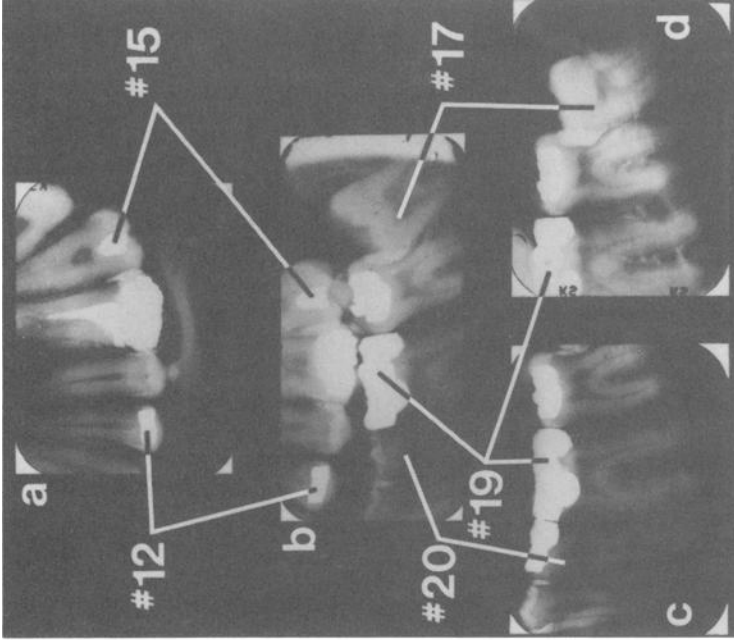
The postmortem and antemortem dental radiographs of Lee Harvey Oswald of the left maxilla and mandible: (a, c, and d) postmortem radiographs, 4 Oct. 1981 and (b) antemortem radiograph, 27 March 1958. No. 12 Maxillary left first premolar—restoration demonstrates identical radiographic morphology in all radiographs. No. 15 Maxillary left second molar—restoration demonstrates identical radiographic morphology in all radiographs. No. 17 Mandibular left third molar—antemortem angulation (b) is duplicated in (d) resulting in similar tooth contacts in postmortem radiographs. No. 19 Mandibular left first molar—restorations demonstrate similar radiographic morphology in (b) (antemortem) and (c) and (d) (postmortem). No. 20 Mandibular left second premolar—similar pulpal anatomy in (b) (antemortem) and (c) (postmortem).
